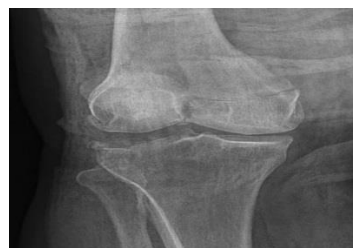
Anteroposterior (AP) x-ray of the knee joint showing distal femoral fracture
